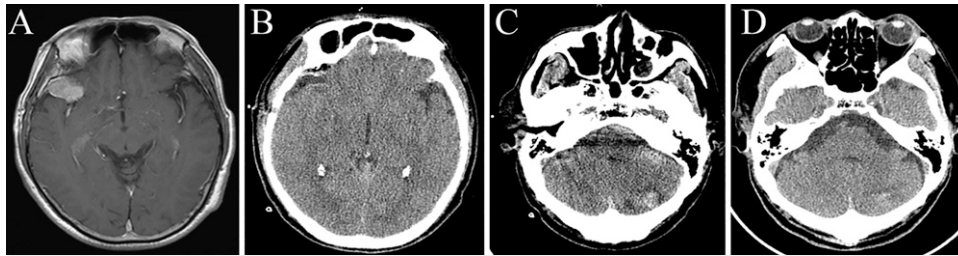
A: Enhanced magnetic resonance imaging of the brain revealed a right sphenoid ridge meningioma. B: Postoperative CT showed that the tumor was completely removed. C: On the first postoperative day, routine CT reexamination revealed left cerebellar parenchymal hemorrhage. D: At 10 days postoperatively, CT reexamination showed that the left cerebellar parenchymal hemorrhage had been absorbed.
